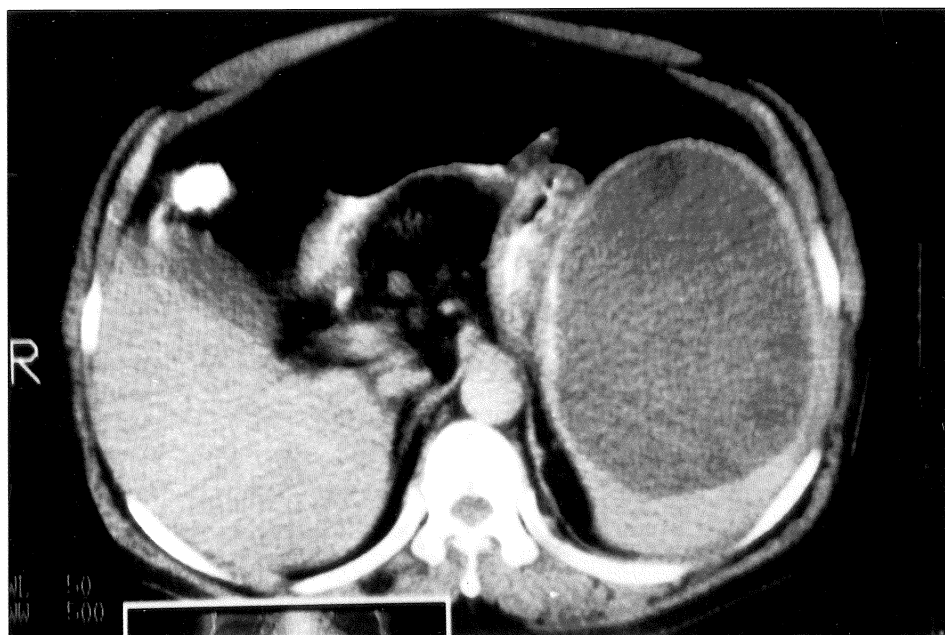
CT-scan showing a large intrasplenic hydatid cyst with clearly defined daughter cysts on the periphery
